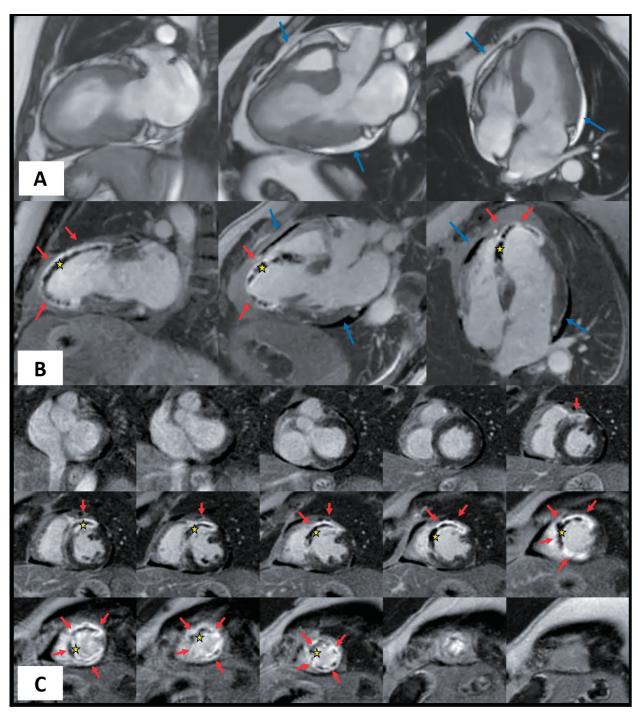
Cardiac MRI performed 96 hours after an anterior myocardial infarction (MI) in a 42-year-old male smoker, following a coronary angiography revealing an ischemic heart disease.
